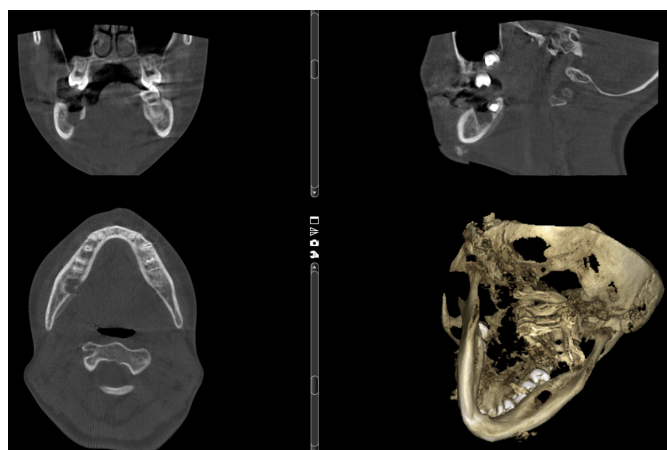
Cone-beam computed tomography at 1 month postoperatively demonstrated bone healing
